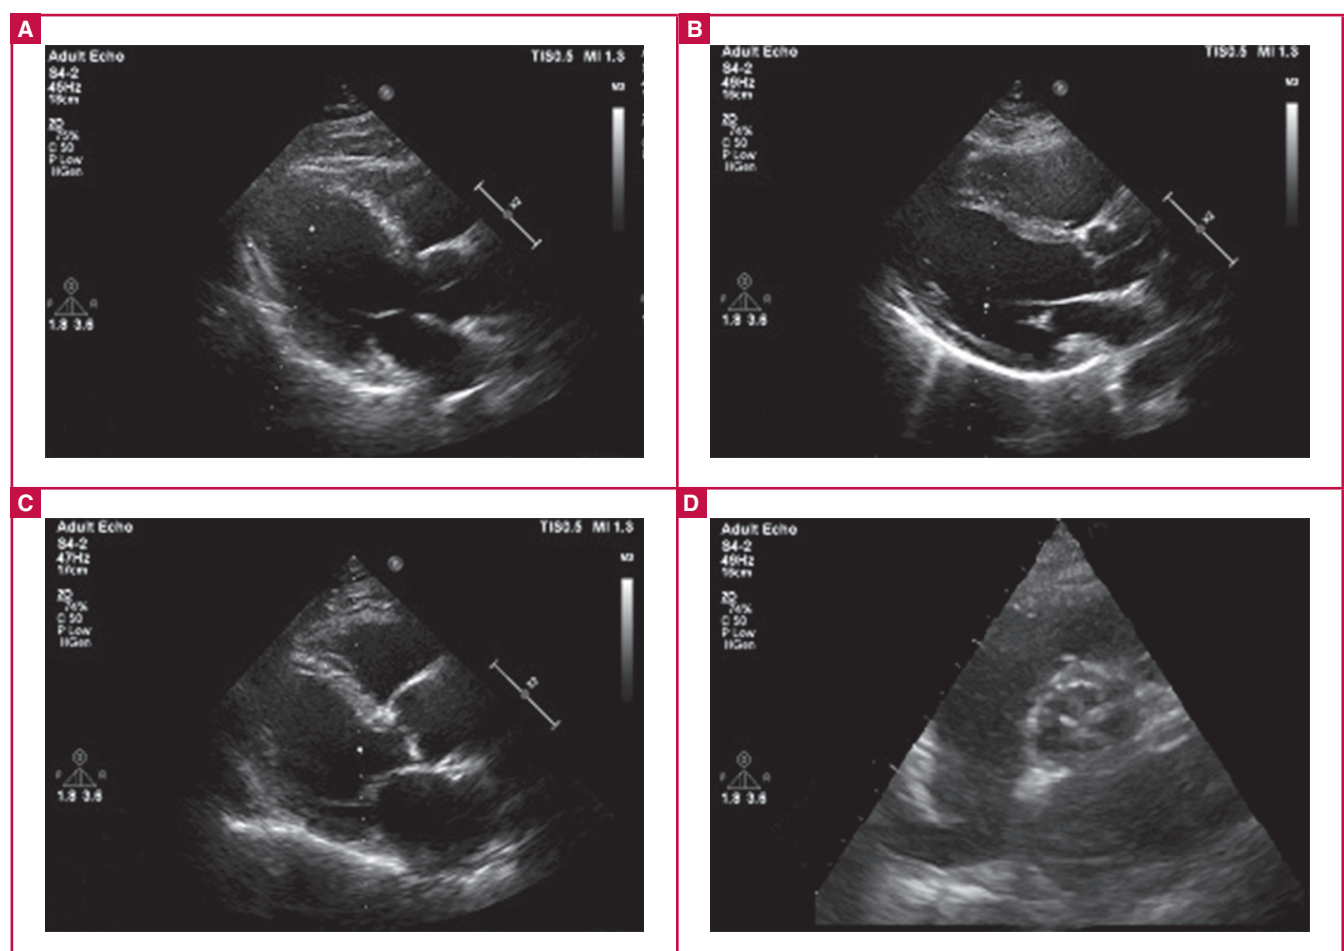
Echocardiographic images of AVS grades showing (A) normal, (B) mild, (C) moderate, (D) severe grades.
